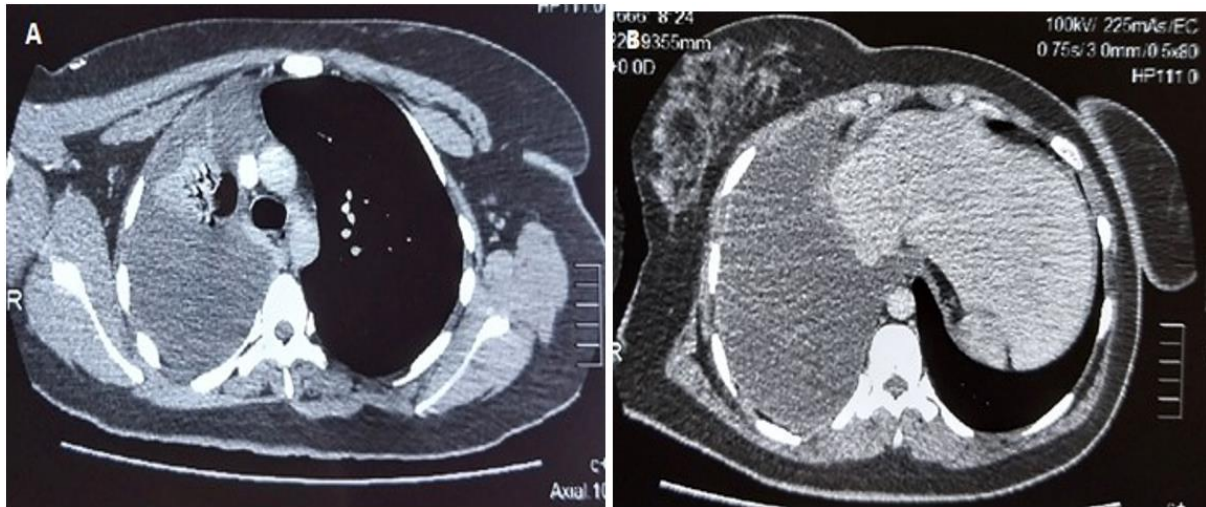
Thoracic CT scan revealing a large right hemothorax.
